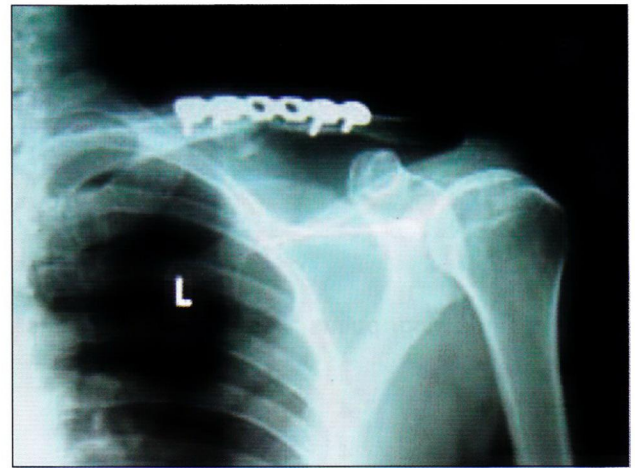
X-ray after two months
